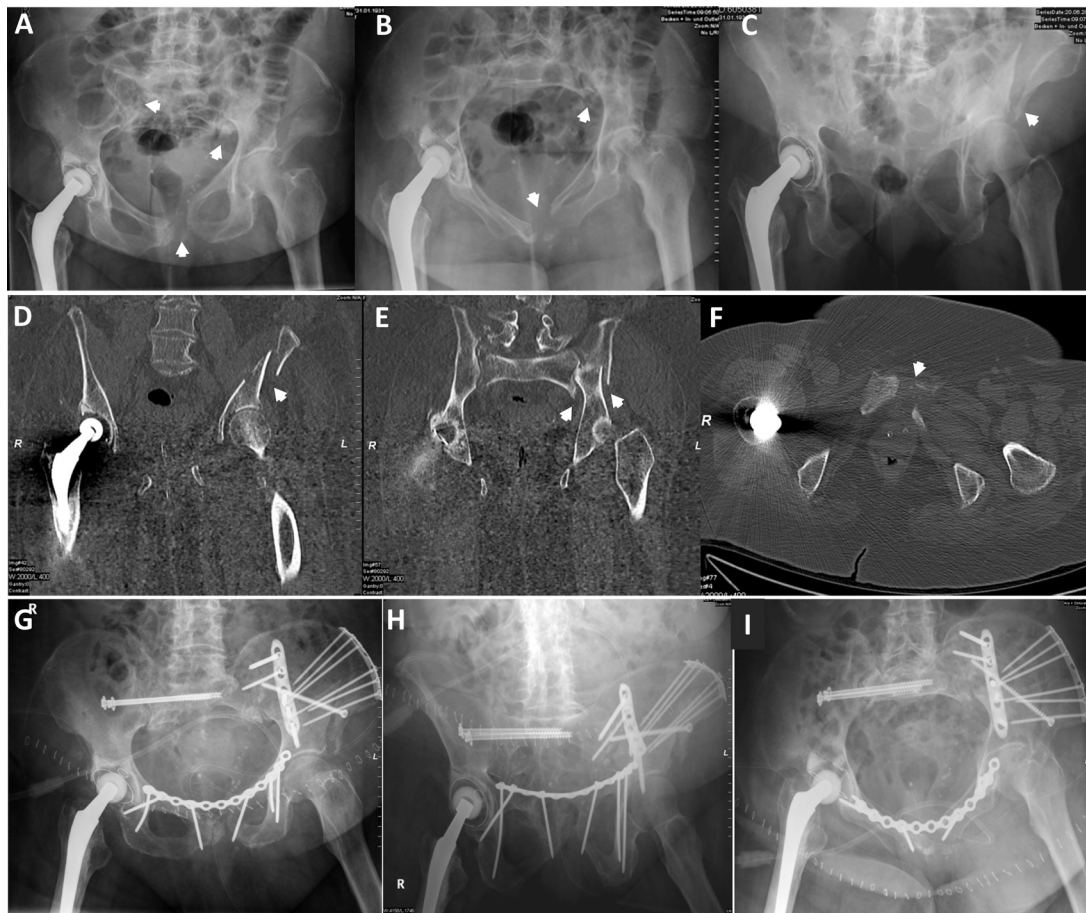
FFP IVC fracture with a combined instability of the anterior and posterior parts of the pelvic ring. Conventional radiographs in a.p. (A), inlet (B), and outlet (C) views as well as the CT-scans (D–F) show severe dislocation of the left hemipelvis. Postoperative a.p. (G), inlet (H), and outlet (I) views demonstrating the result after iliosacral screw osteosynthesis on the right site, open reduction and internal fixation of the dorsal disruption on the left site using a bridging angular stable plate and a conventional plate, and a bridging plate osteosynthesis of the anterior part of the pelvis.
